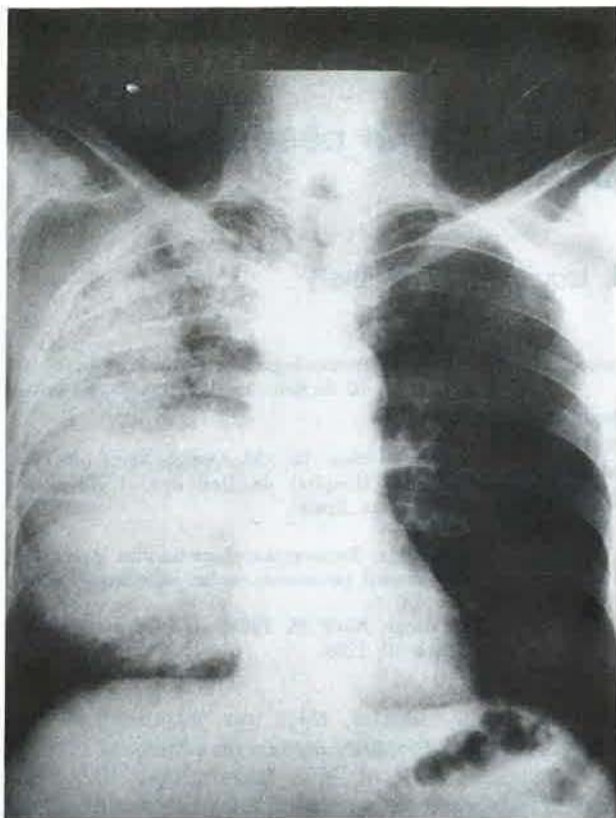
Chest roentgenogram 14 days after admission showing radiological progression to include the right lower lobe; uniform central area corresponds to a posterior empyema. PA view left, right lateral view right.
